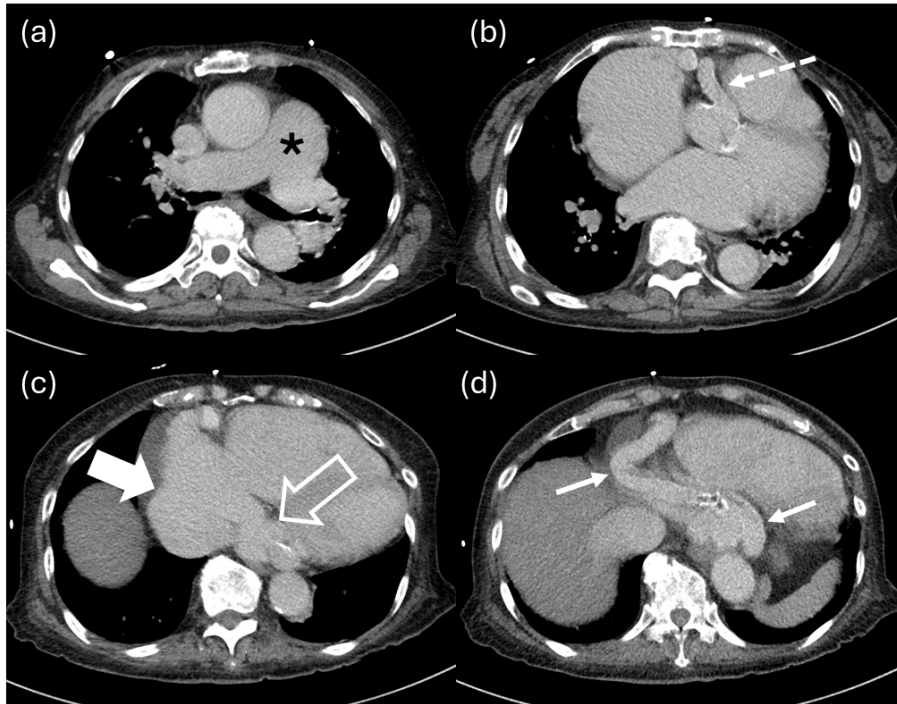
Selected slices from CT pulmonary angiogram – (a) Dilated pulmonary trunk measuring up to 4.3 cm in diameter (asterisk). (b) Origin of dilated RCA measuring up to 1.7 cm in diameter (dashed arrow). (c) Drainage into a dilated distal coronary sinus (hollow arrow) and enlarged right atrium (solid broad arrow). (d) Tortuous course of the RCA (arrows) and inferior vena caval reflux of contrast. CT acquisition details: Siemens, 120kV, 154 mAs, 1 mm slice thickness, 60 ml IV Omnipaque 350
